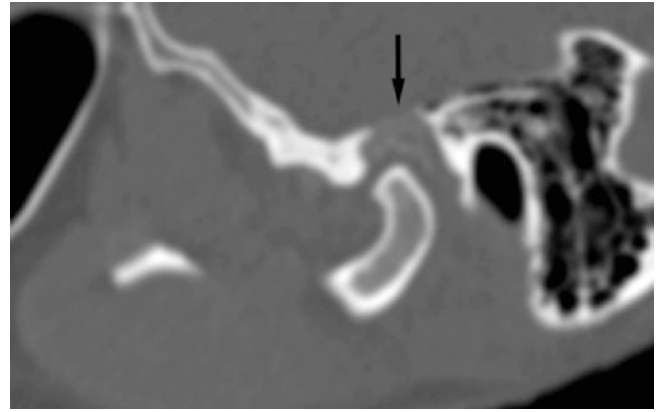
Synovial chondromatosis; 53-year-old female. (A) Clinical photograph shows swelling of the right TMJ (*arrow*). (B) Panoramic view shows calcifications in the right TMJ area (*arrow*). (C) Coronal and (D, E) oblique sagittal CT images of the right (D) and normal left (E) joint show soft-tissue calcifications in the right joint (*arrow*) and periosteal reaction on the right ramus (*arrowhead*). (F) Axial CT image shows several small soft-tissue calcifications (*arrow*). (G, H) Axial T2-weighted MRI shows multiple small low-signal nodules (*arrow*)
